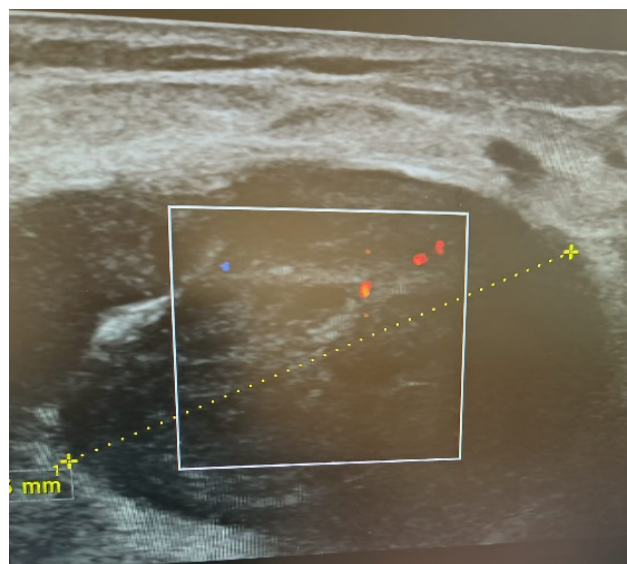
Ultrasound aspect of inguinal node.
